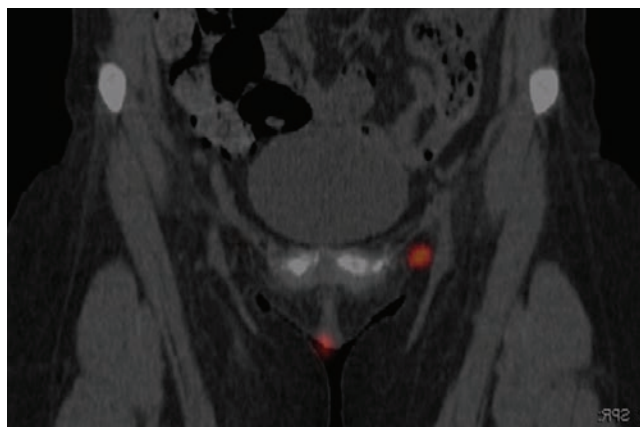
SPECT/CT demonstrating left sentinel lymph node just medial to femoral vein. SPECT/CT provides superior localization of sentinel lymph nodes compared with 2-dimensional lymphoscintigraphy. The number of sentinel nodes identified should correspond to the number removed at surgery.
